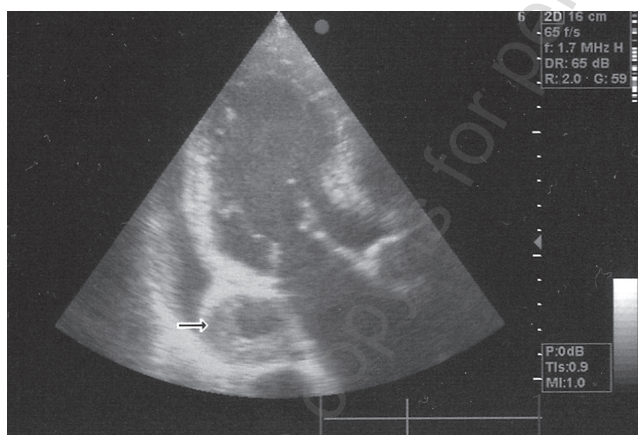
Echocardiography of giant coronary artery aneurysm (black arrow) in 3 chambers view.
